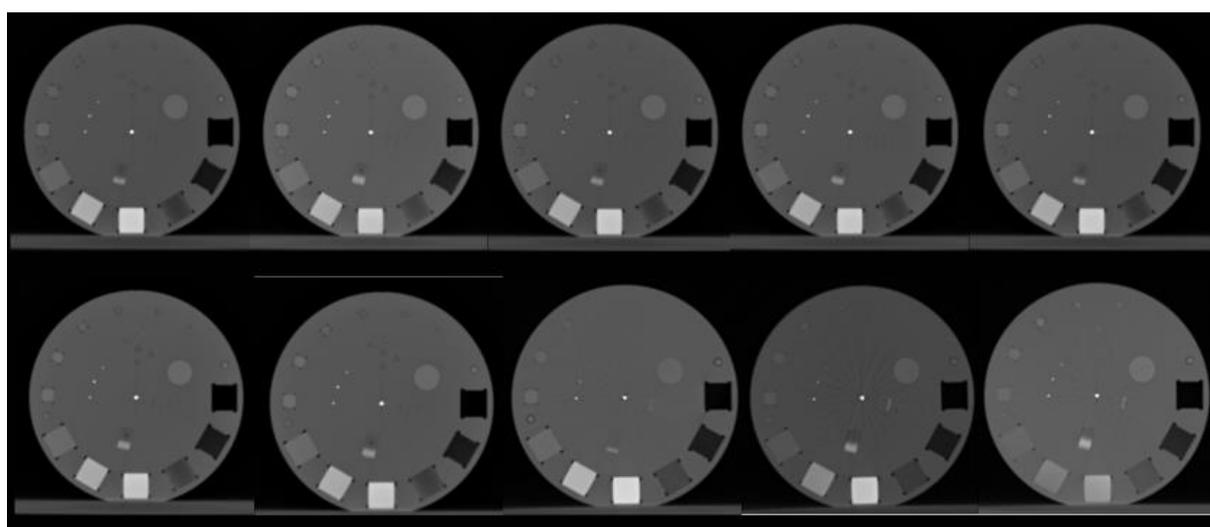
CT scanning reproducibility images.
